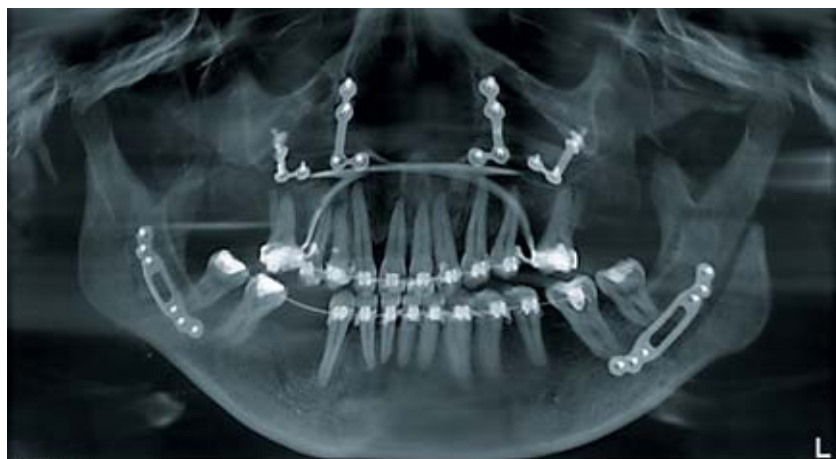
Postoperative orthopantomogram in March 2016
